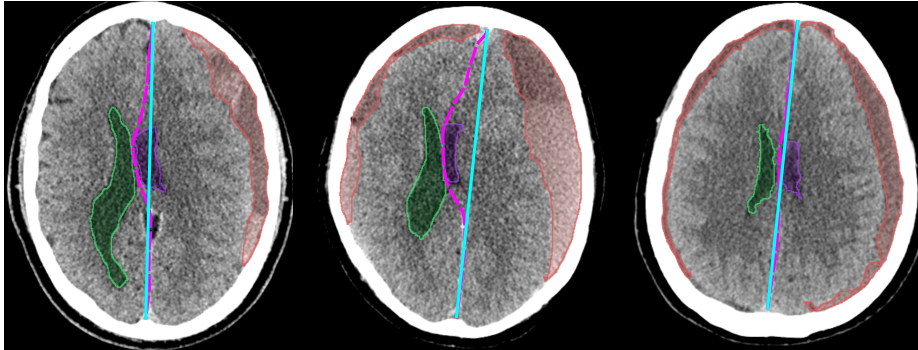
CT scans of cSDH patients selected for surgical intervention, showing the ideal midline (blue), shifted midline (pink), cSDH (red), left ventricle (purple), and right ventricle (green). Left: a unilateral hematoma with midline shift. Center: a bilateral hematoma with midline shift. Right: a bilateral hematoma without midline shift.
